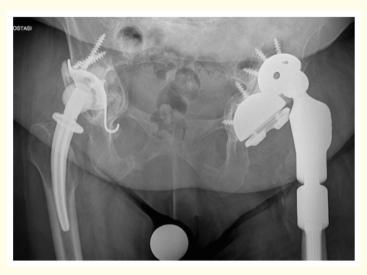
X-ray after dislocation and lodging in the proximal cup.
